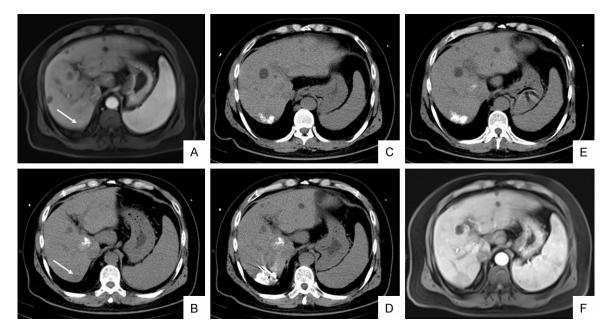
A 53-year-old male patient with HCC who underwent percutaneous lobaplatin injection (PLI) and RFA. (A, B) The lesion in S7 segment (white arrow) adjacent to diaphragm (A, MRI arterial phase; B, CT plain scan). (C) The high-risk part of S7 had been injected with lobaplatin. (D) The RFA needle was guided into the non-high-risk part of the tumor. (E) After treatment, CT scan was performed. (F) One month after operation, the tumor was completely ablated.
